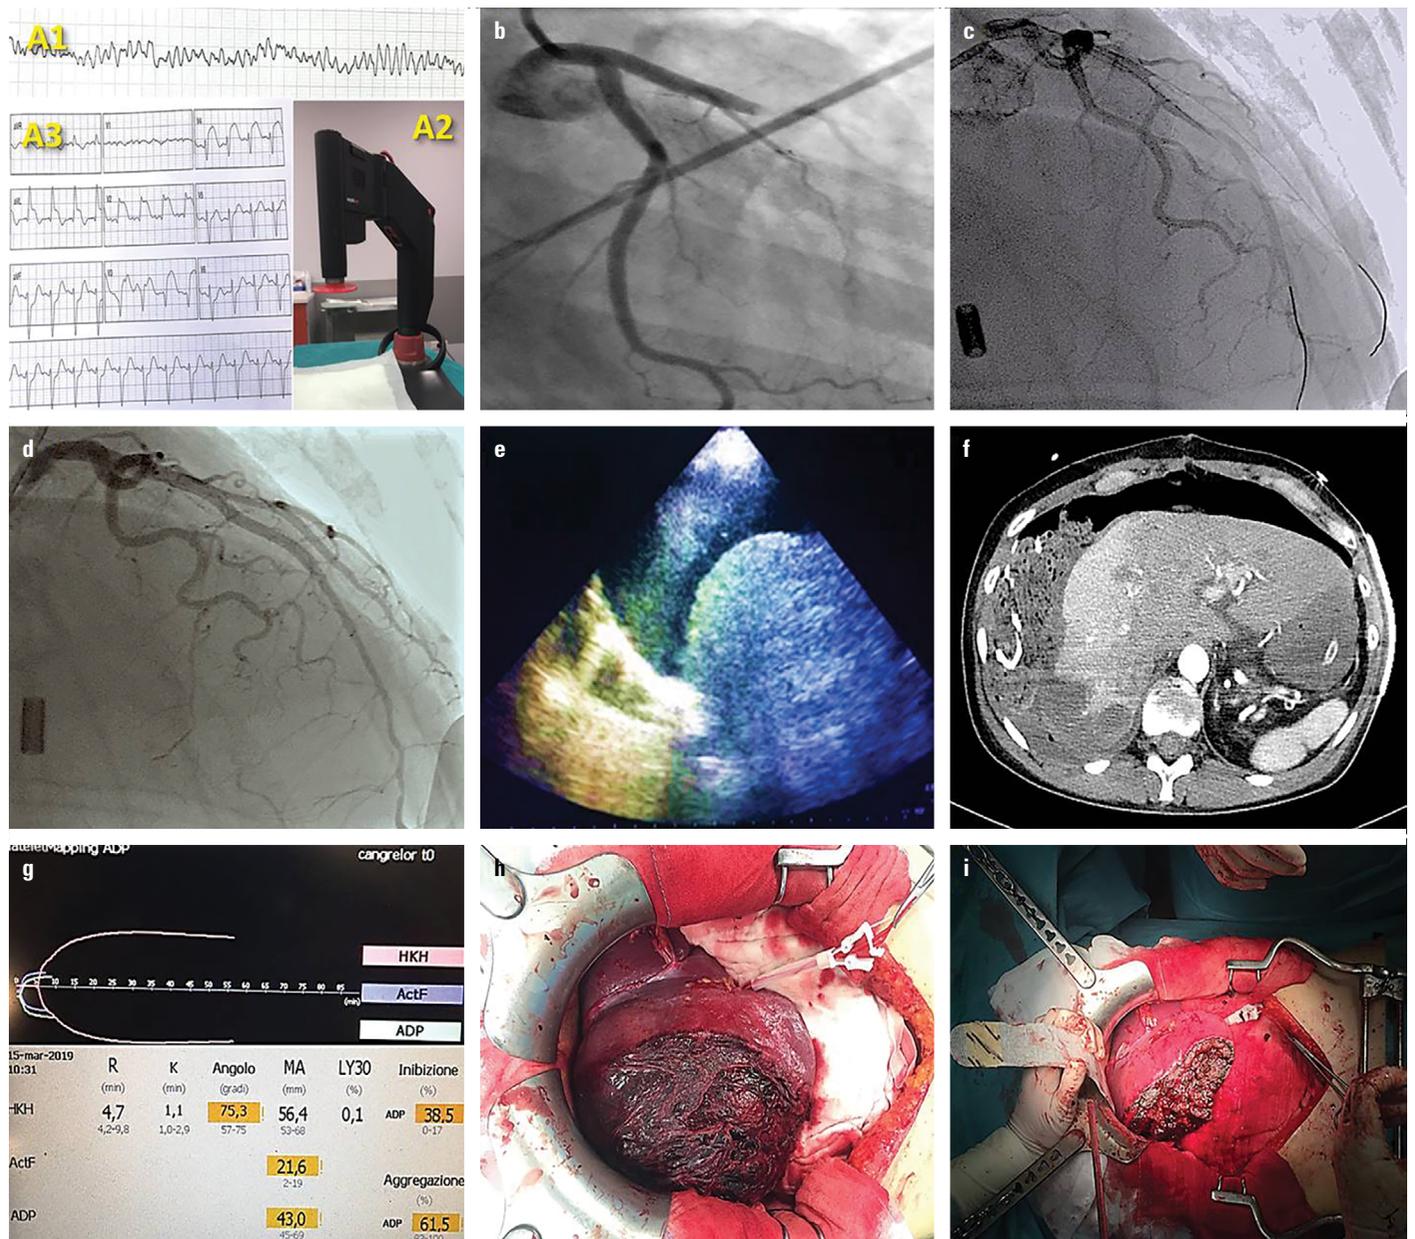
(a1, a2, a3) EKGs and chest compression device; (b, c, d) Interventional coronary angiographies; (e) trans-hepatic ultrasound view of pleural and perihepatic fluid collection; (f) Abdominal CT after perihepatic packing; (g) Thromboelastography/platelet function assay (TEG 6s Haemonetics®); (h) Right-sided view of the enlarged right liver lobe hematoma; (i) The remaining liver parenchyma after emergency liver resection
